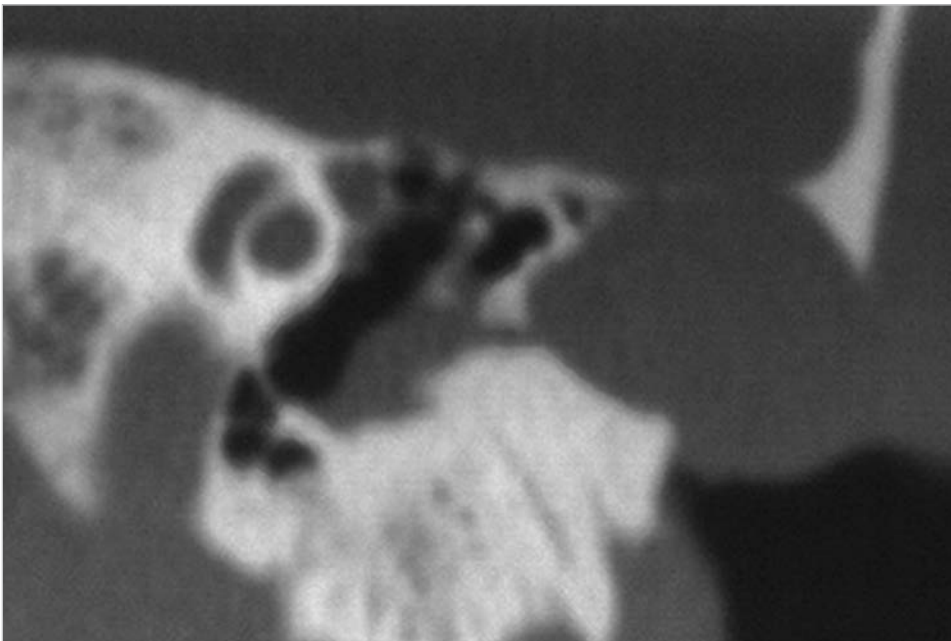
A case of iatrogenic cholesteatoma in the external auditory canal. The patient underwent surgery for exostosis, and hearing loss followed the surgery. The preoperative coronal CT demonstrates formation of large cholesteatoma eroding the middle fossa plate, and presence of exostosis just lateral to the tympanic membrane.
